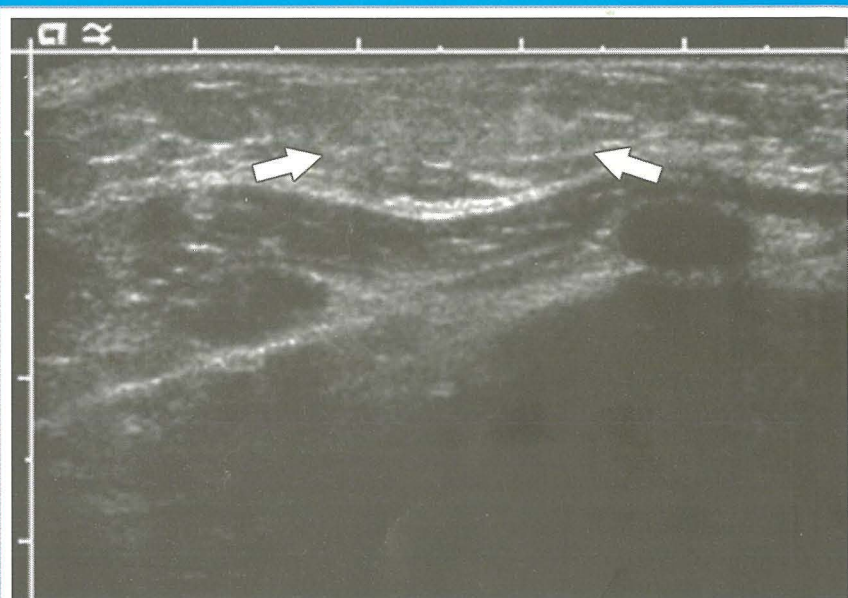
The 5 Tanner stages of normal pubertal breast development can be recognised on ultrasound. Tanner stage 1 appears as a small area of ill-defined echogenic tissue in the retroareolar region (arrows).
